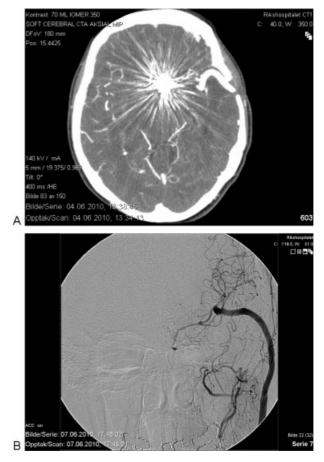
The patient underwent a high-flow venous graft bypass between the left external carotid artery and the middle cerebral artery (MCA). The internal carotid artery was occluded proximally in the neck. (A) Axial computed tomography angiography demonstrating the patent graft to MCA and coil artifacts. (B) Digital subtraction angiography anteroposterior view demonstrating filling of the extracranial-intracranial bypass.
